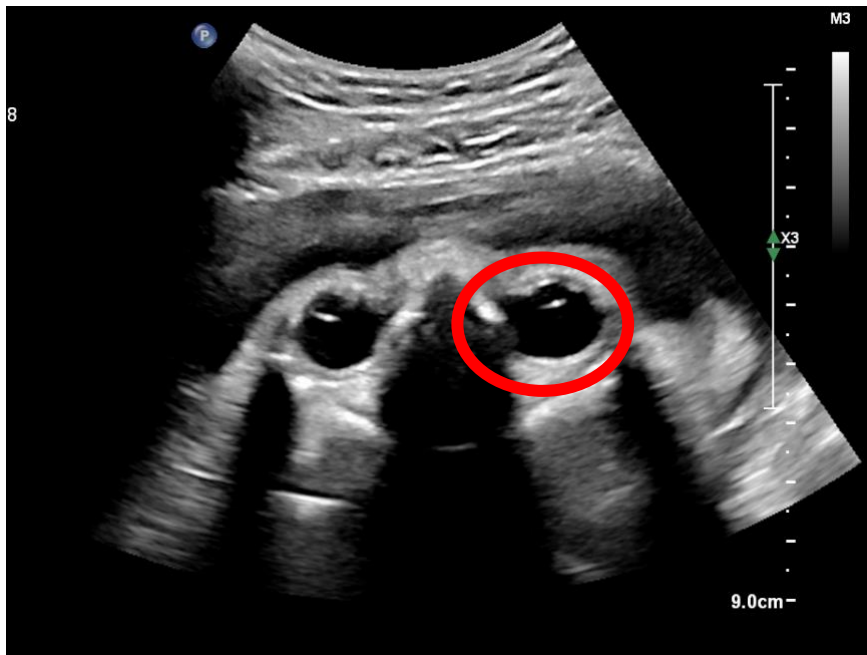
An image of a 2D ultrasound of a fetal head in the transverse plane. The acoustic reflection from the lens of the right eye is highlighted in the red circle.
